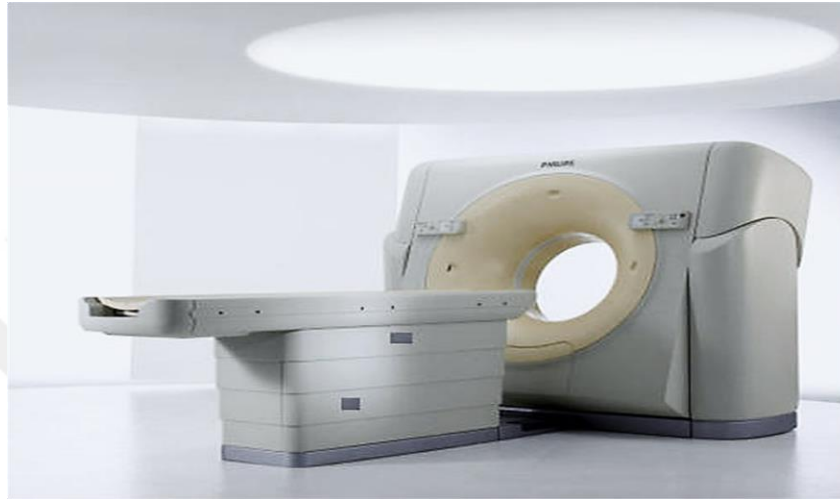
CT scan 64 slice Philips [36].
